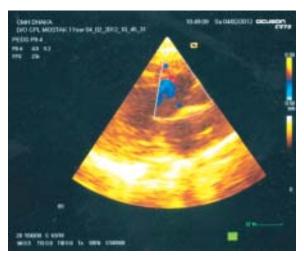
Echocardiography of the patient before surgery.
